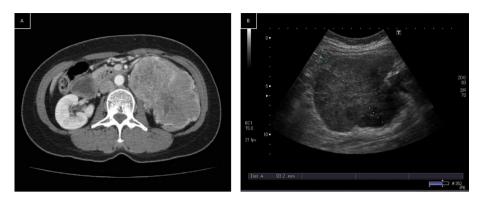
(A) CT showed a large tumor, measuring up to 12 cm, in the left abdomen (B) Abdominal echo showed a heterogeneous and hypoechoic lesion with hypervascularity arising from the small bowel wall.
